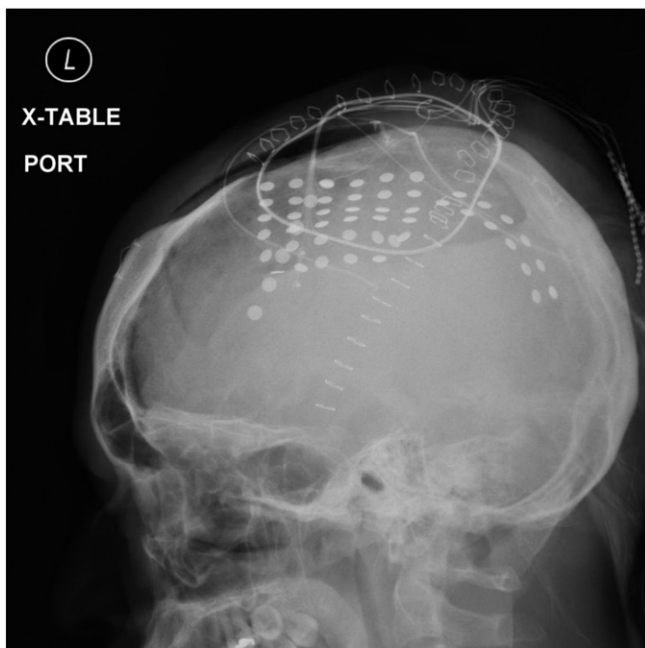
XRAY images of the SDG in the patient.
